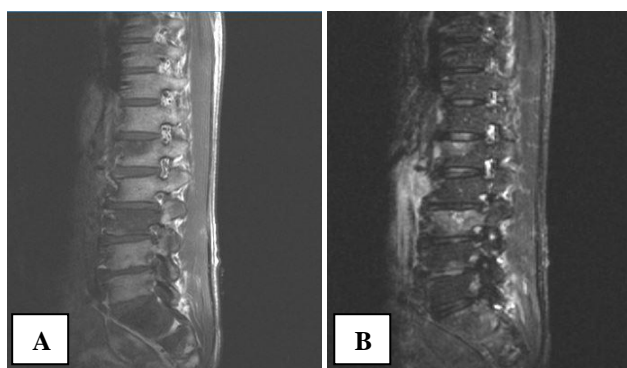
Lumbosacral MRI with contrast on A. T1WI and B. T2WI shows mild compression on anterior corpus vertebrae L1 and L2, multiple lesion with undefined margin on the corpus vertebrae L1, L3, L4, S1, and S2 supporting the vertebral metastasis
